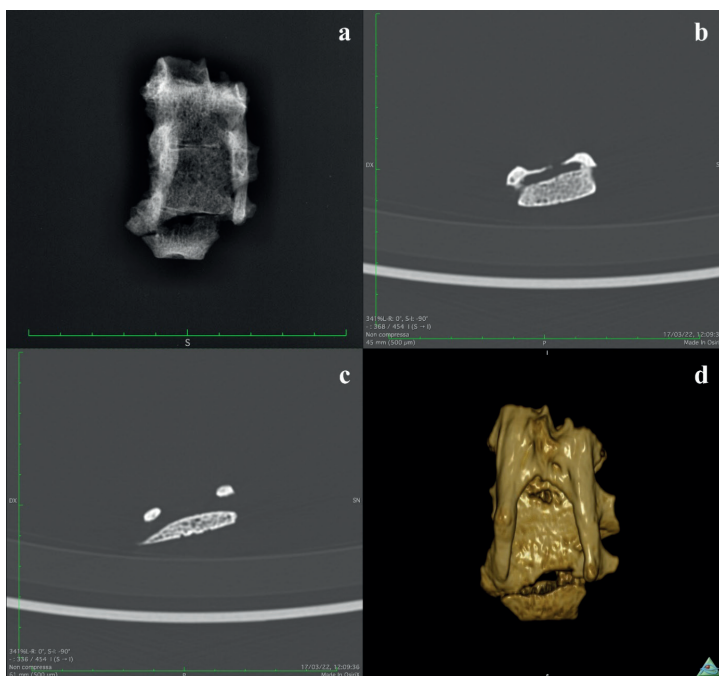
a. X-ray image of the sacral fragment in postero-anterior projection
